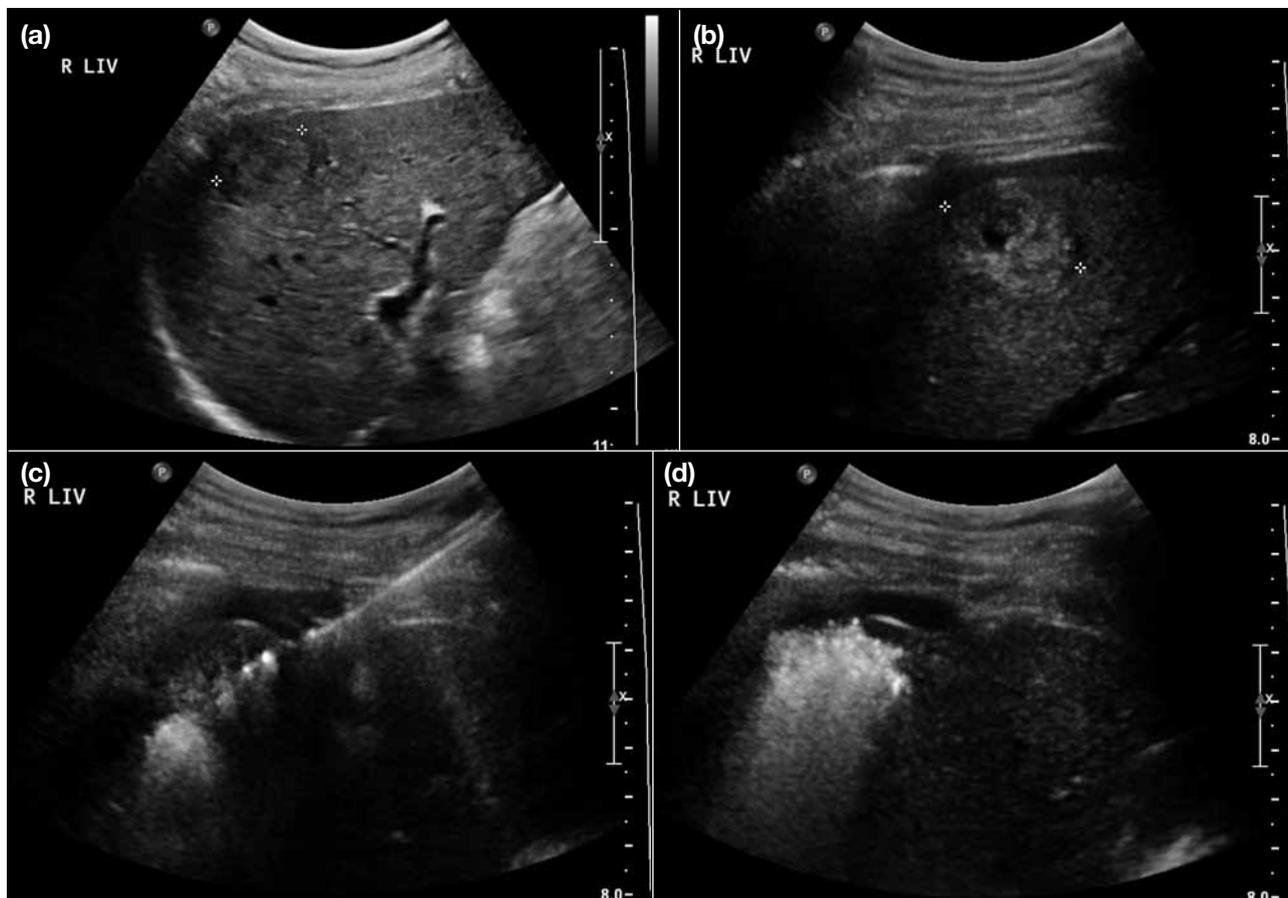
Ultrasonography showing (a) a heterogeneous hypoechoic lesion at segment VI (outlined by calipers), (b) administration of artificial ascites (outlined by calipers), (c) insertion of a cluster Cool-tip probe, and (d) completion of one cycle of radiofrequency ablation.
